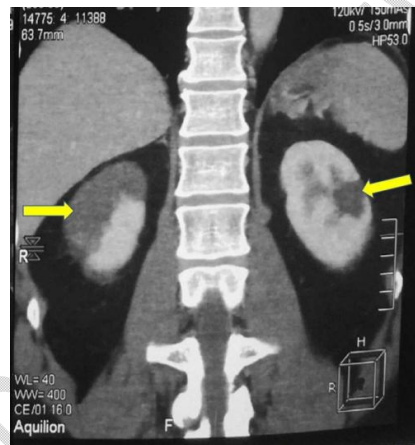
CT image showing bilateral renal parenchyma infarction (ischemia of 2/3 of the right renal parenchyma)
